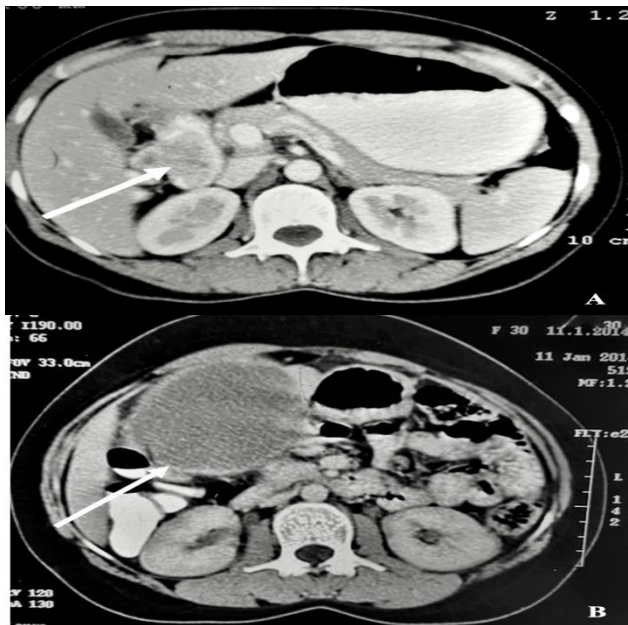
(A) CT of tumour originating from second part of duodenal wall (solid white arrow); (B) CT of hypodense tumour lesion Originating, from anterior wall of stomach antral region (solid white arrow).
